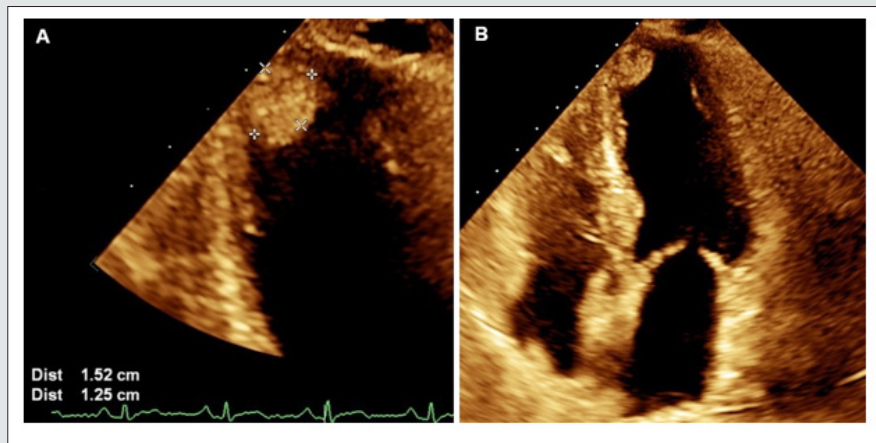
Transthoracic echocardiogram. Apical axis 4 chambers.
